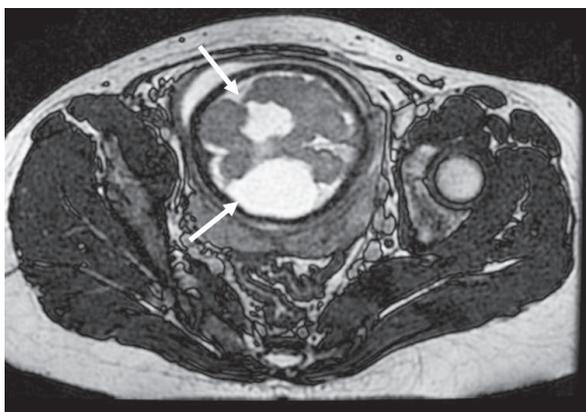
Case 19: FIESTA fetal MRI sequence showing bilateral open lip schizencephaly (arrows) in a 31-week fetus. Postnatal MRI (not shown) confirmed bilateral schizencephaly with polymicrogyria. Baby had increased tone in all limbs, dystonia and roving nystagmus at 1 year of age.
